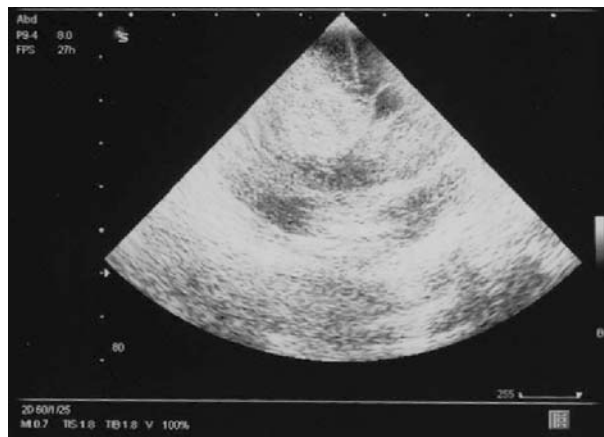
Cerebral ultrasonography after the administration of rFVIIa.
